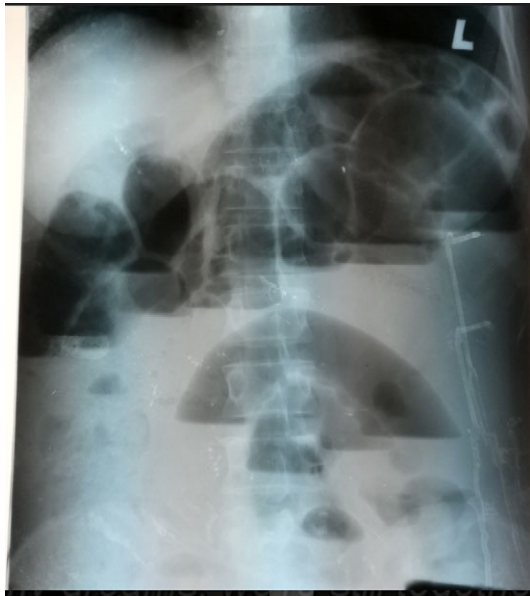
Erect abdominal X-ray showing multiple air fluid level with dilated small bowel loops.
